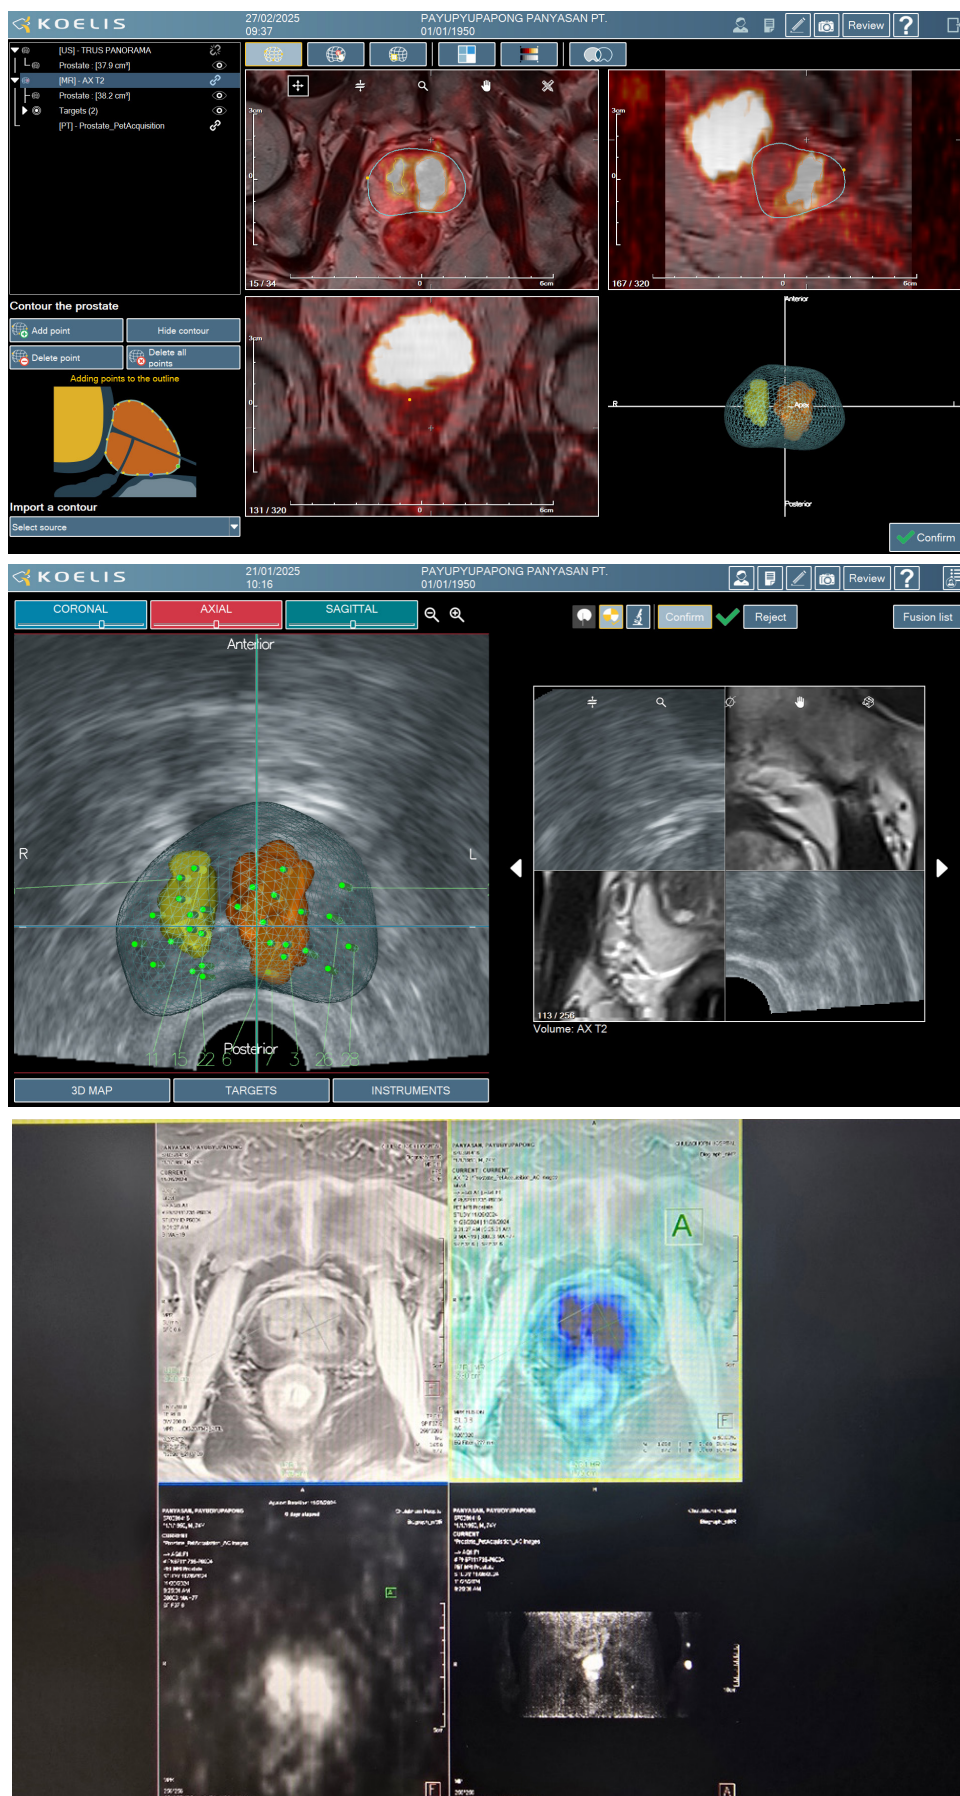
MRI-PET fusion prostate biopsy in case 2
